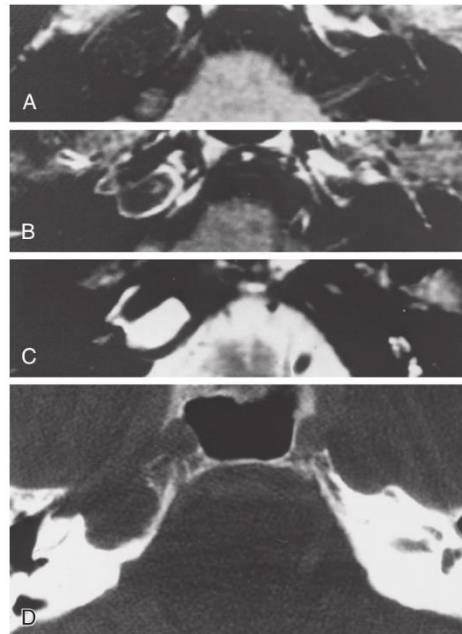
A to C, Axial magnetic resonance images of a petrous apex mucocele: T1-weighted without gadolinium (A), T1-weighted with gadolinium (B), and T2-weighted (C). The lesion is hypointense on the T1-weighted image and shows only rim enhancement with the addition of gadolinium. Note the hyperintensity of the mucocele on the T2-weighted image. D, Axial computed tomography scan of the same lesion. Note that the expansile lesion has eroded the petrous apex.
